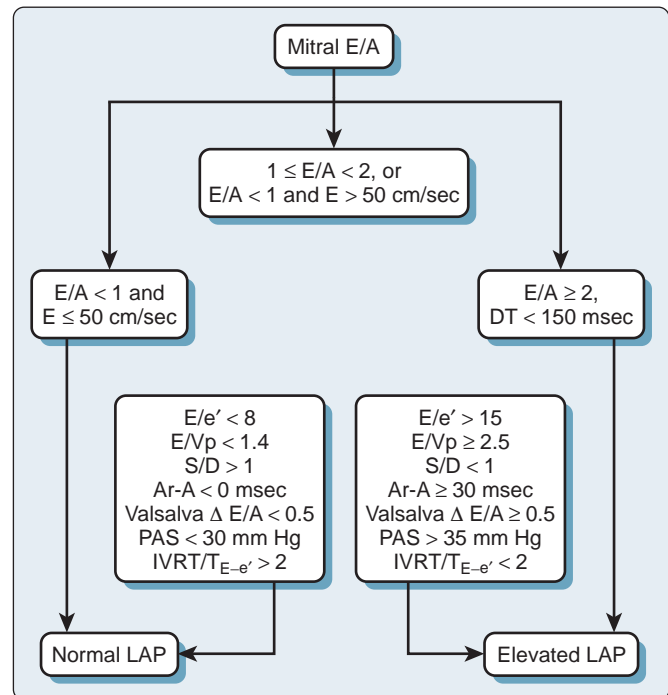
Evaluation of left atrial pressure (LAP) with depressed ejection fraction. A, Late diastolic transmitral velocity; Ar-A, difference between pulmonary venous atrial reversal duration and transmitral A-wave duration; Avg, average; DT, E-wave deceleration time; E, early diastolic transmitral velocity; e', early diastolic tissue Doppler velocity; IVRT, isovolumic relaxation time; LA, left atrial; Lat, lateral; PAS, pulmonary artery systolic pressure.
